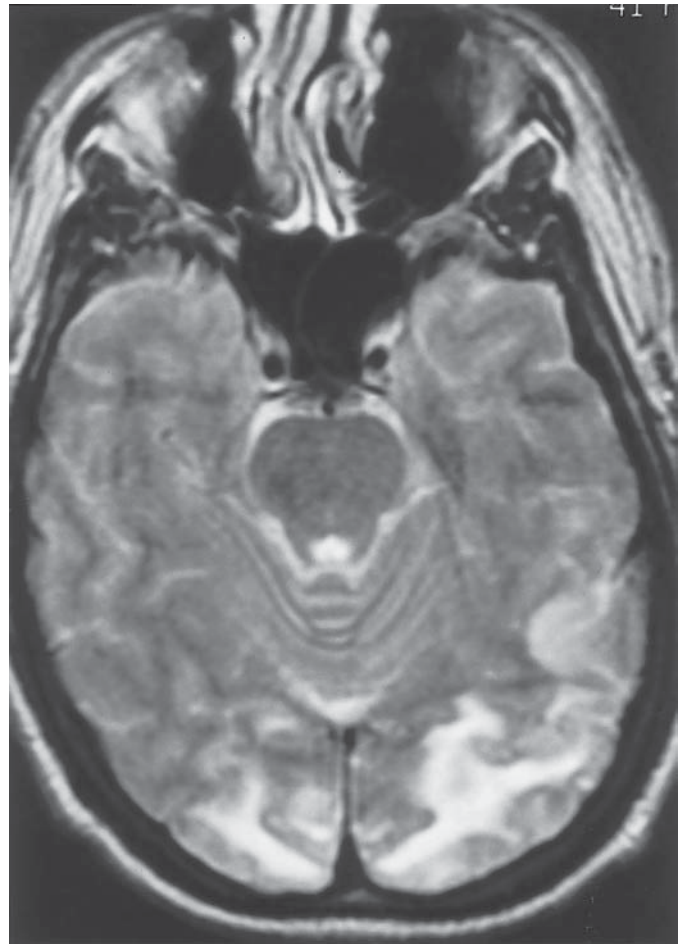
This 51-yr-old patient developed decreased visual acuity 3 d after commencing cyclosporine therapy. The patient had recently undergone bone marrow transplantation for chronic myelogenous leukemia. T2-weighted MRI shows a pattern of bilateral increased signal in the subcortical occipital white matter typical of cyclosporine toxicity.
